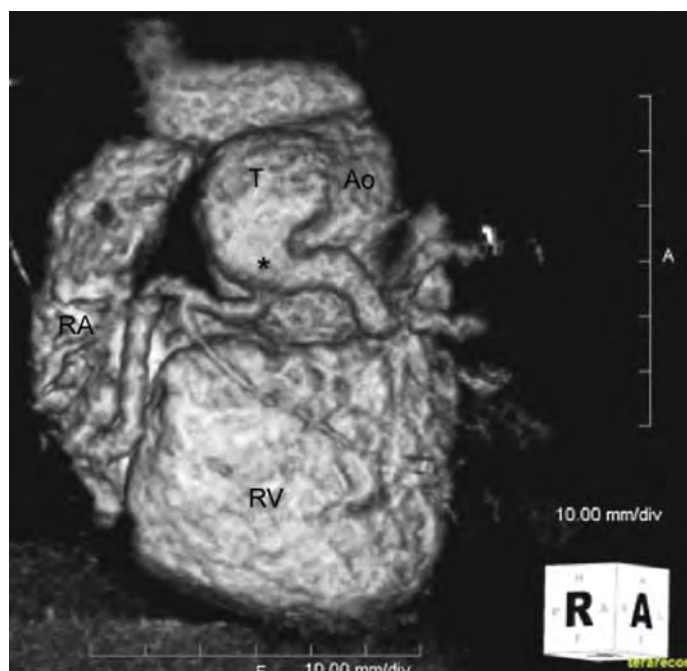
Aorto-left ventricular tunnel (AoLVT) and anomalous origin of the right coronary artery. This image is a surface rendered three-dimensional reconstruction created during a cardiac CT scan of a patient with a type 4 AoLVT. The AoLVT (T) arose from the tubular ascending aorta (Ao) and emptied into the left ventricle in the usual manner. This image reveals that the right coronary artery (*) originates from the distal aspect of the tunnel. The unbranched segment is short with a large anterior branch and a small right/posterior branch noted immediately beyond the asterisk. A, anterior; R, right; RA, right atrium; RV, right ventricle.
